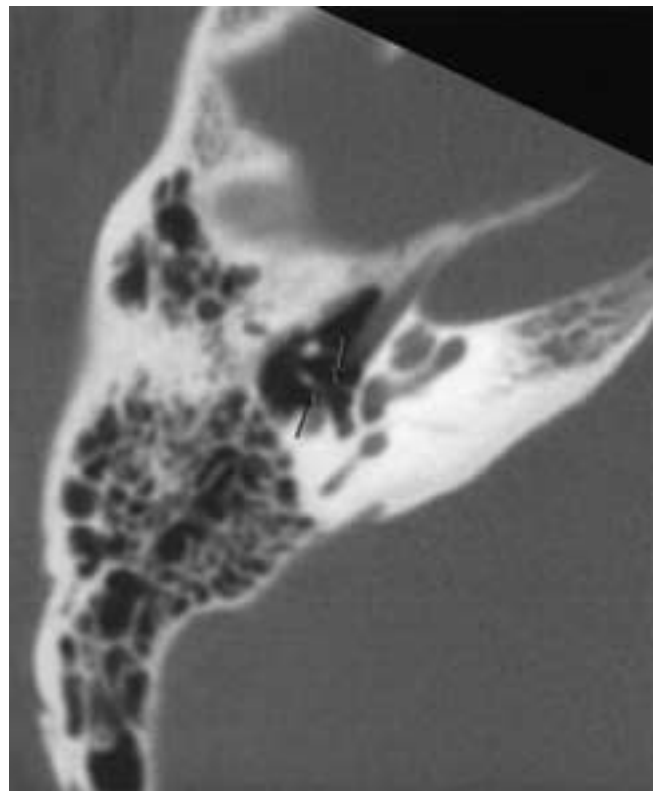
Incudostapedial subluxation. Axial CT image, right ear. The lenticular process is posteriorly positioned (arrows) relative to the stapes head.
